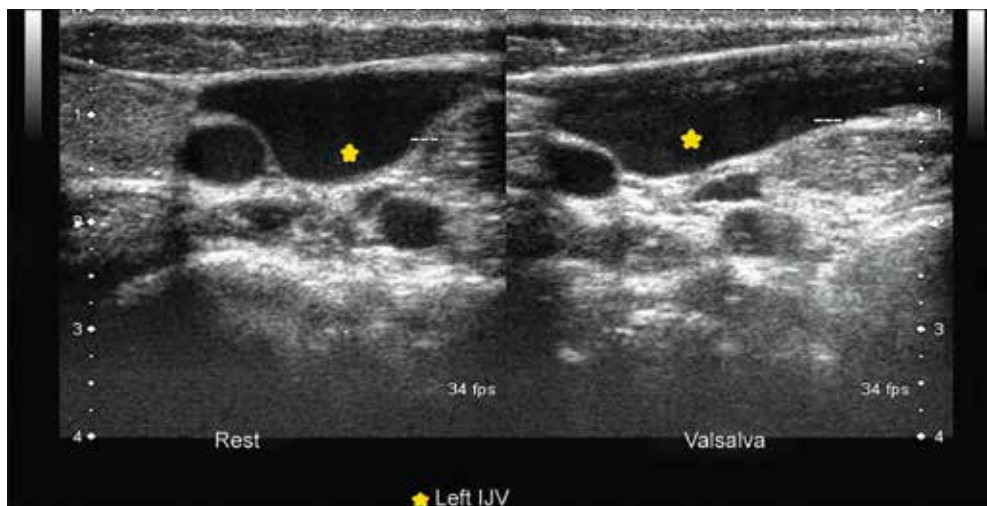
Transverse ultrasound showing left IJV at rest and with valsalva manoeuvre
